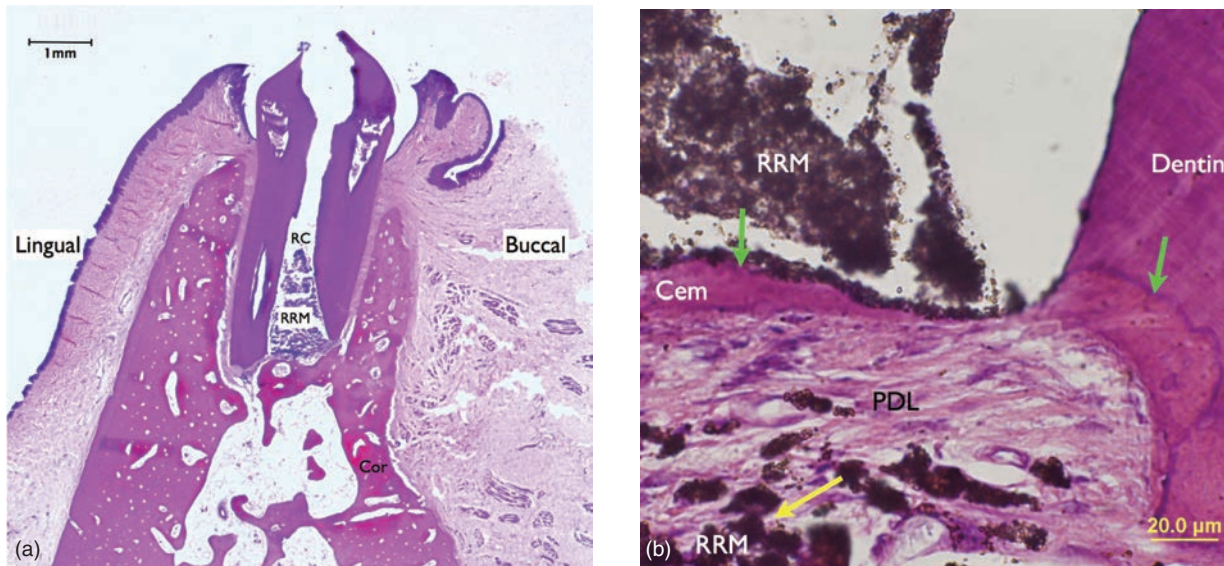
Periapical tissue response in root filled with EndoSequence Root Repair Material. (a) Overview of cross-section: re-establishment of buccal cortical plate and periapical tissue reformation. (b) Magnified view of the root end surface. No inflammatory cells were found in the periapical area near the exit of the root canal. RRM remnant in periapical tissue did not induce inflammatory reaction (yellow arrow). Cementum-like tissue formed on the resected root end surface and RRM root end filling (green arrow) with fibrous insertion from the adjacent PDL-like tissue.
